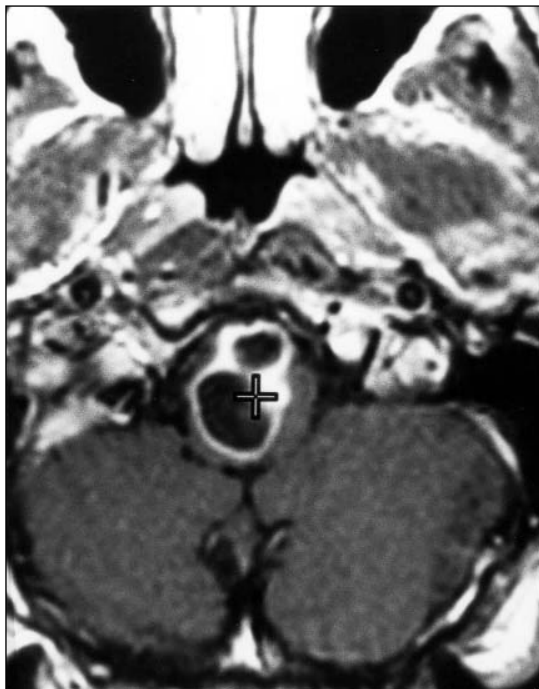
A: Axial T1-weighted contrast enhanced MR image showing a large cystic medullary glial tumor.
